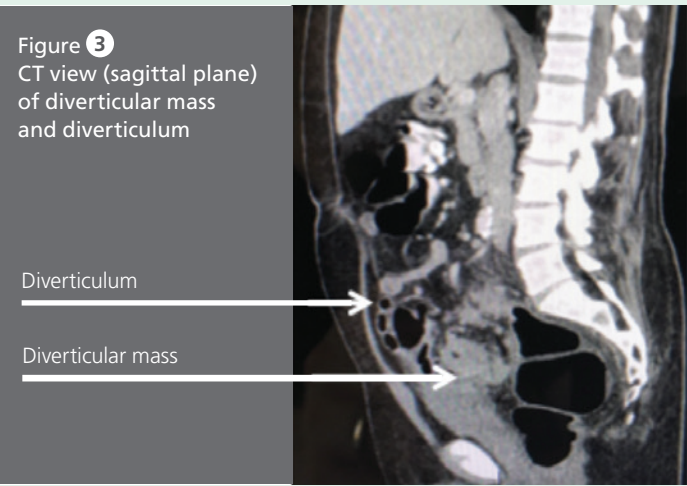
CT view (sagittal plane) of diverticular mass and diverticulum
